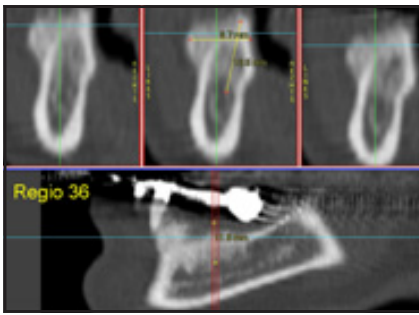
CT scan after 24 weeks.
